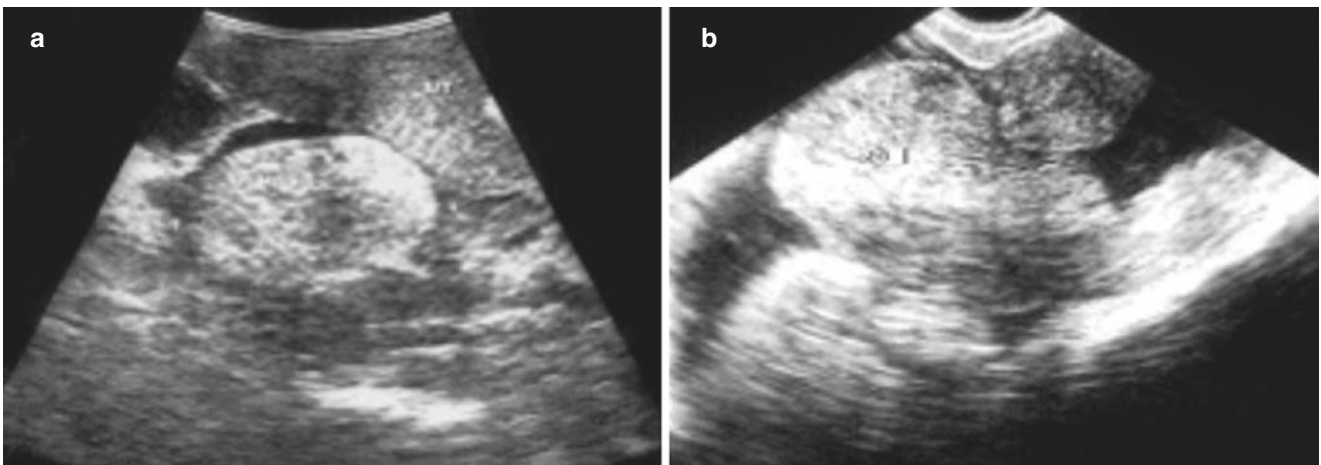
Ovarian teratoma (I). (a, b) Ultrasonographic images show hyperechoic dough sign
